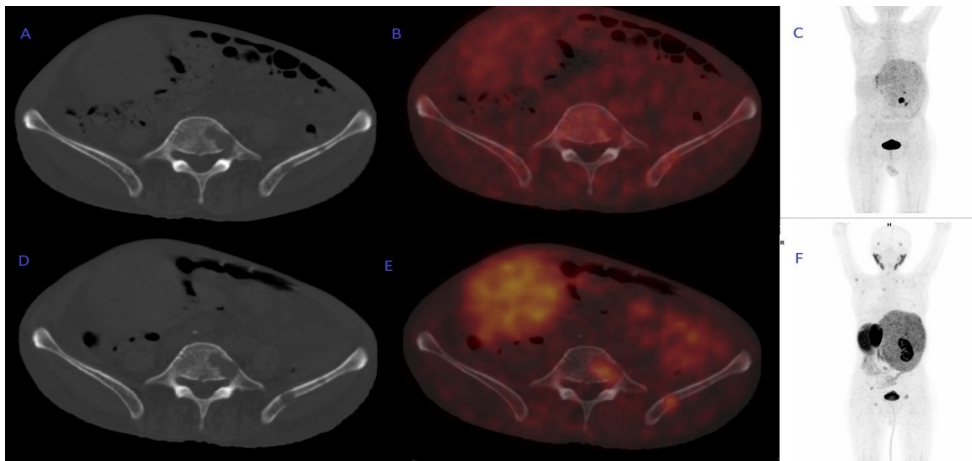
Lesions observed in the L5 vertebral body and left iliac bone of a patient diagnosed with HCC on FDG PET/CT study; axial tomography image (A), axial positron emission tomography/computerized tomography image (B), MIP image (C), and in the Ga-68 PSMA PET/CT study; axial tomography image (D), axial positron emission tomography/computerized tomography image (E), MIP image (F) of a patient with HCC.
